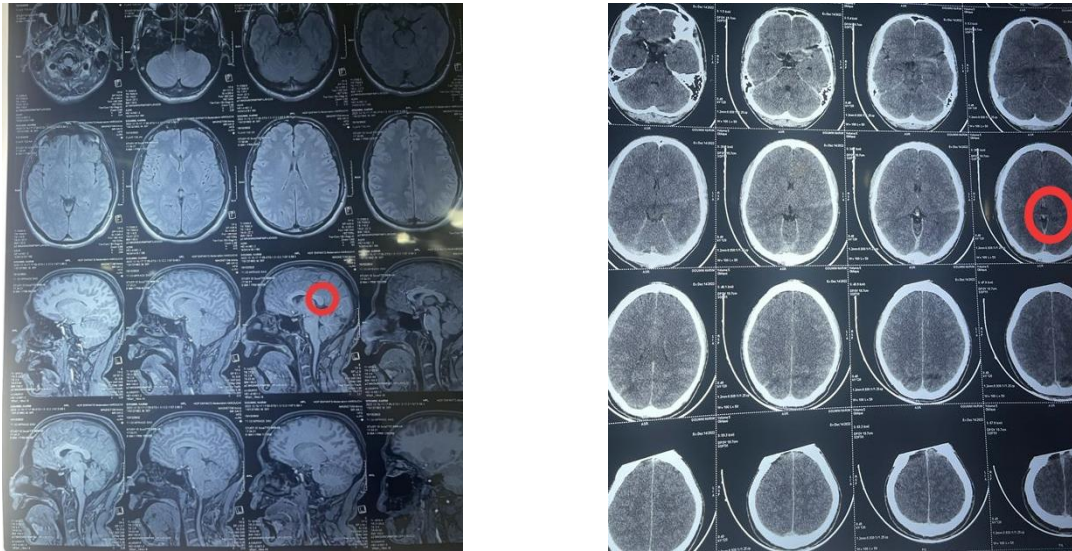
A cerebral MRI showed a hypersignal of selenium from the corpus callosum, corresponding to a hematoma of the corpus callosum.
